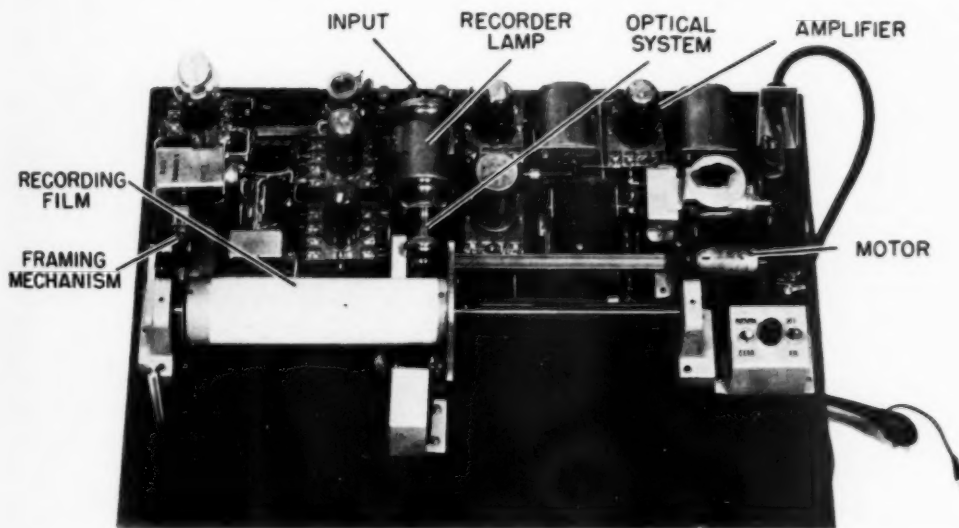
Roentgenographic facsimile recorder.
